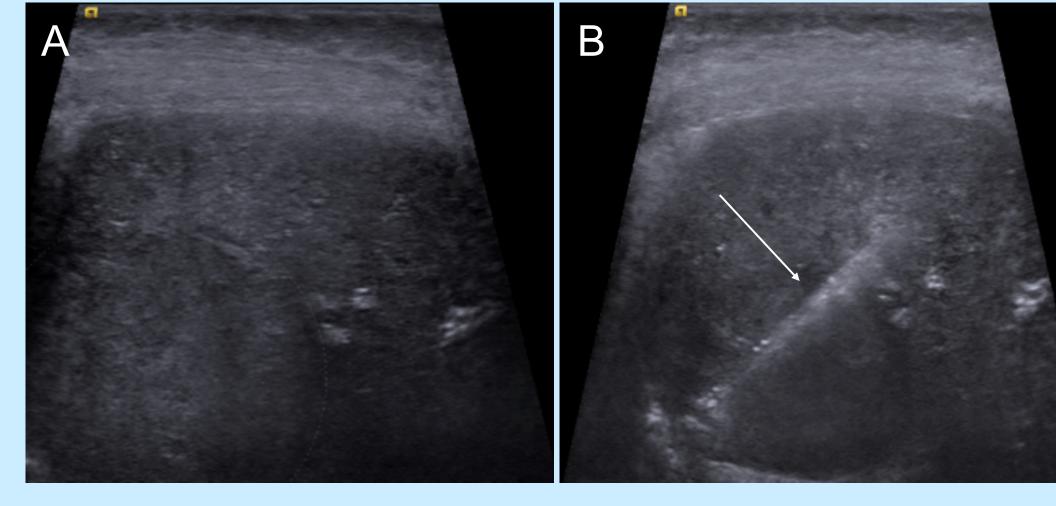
Ultrasound images of the liver demonstrating (A) the predominantly isoechoic segment VII lesion accentuated by the dotted line for ease of visualization and (B) the hyperechoic MWA antenna (Arrow) penetrating the lesions just prior to therapy.
